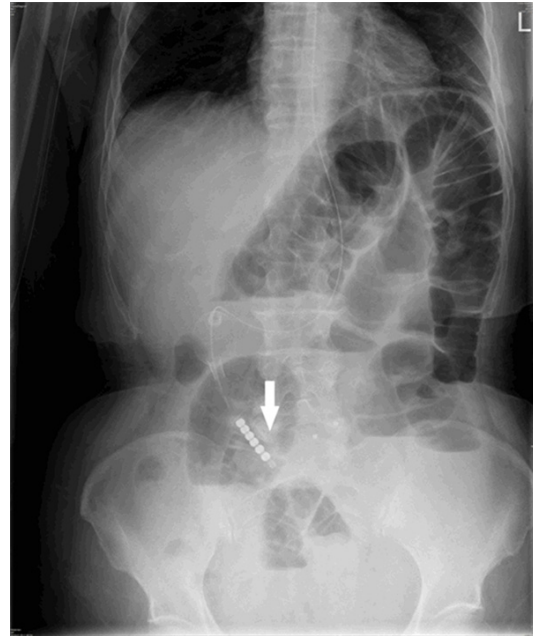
Abdominal X-ray taken in a standing position after the insertion of an intestinal obstruction catheter.
